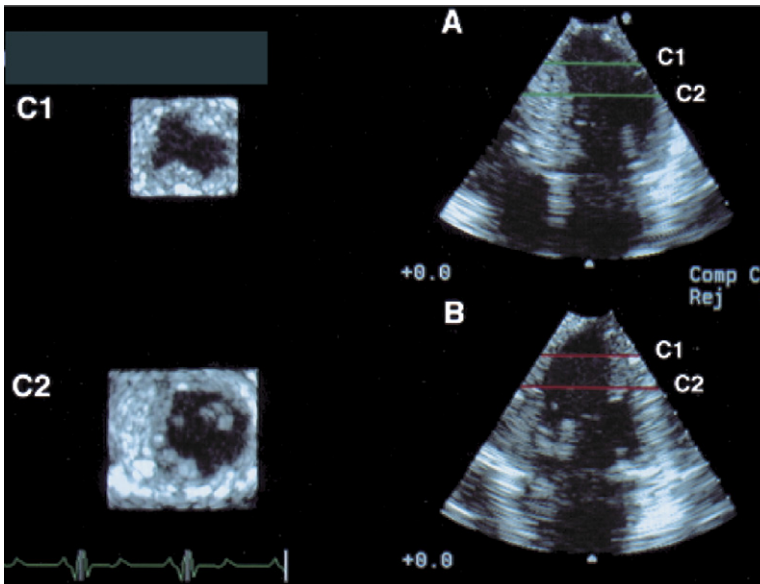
Real-time 3D echocardiograph C-scan images, Volumetrics, Inc. The images shown are apical view of the heart on right, four chamber on top, and two chamber on the bottom. On the left are short axis or C scans of the LV derived from perpendicular cuts through the apical views on the right. (Courtesy of David Adams, RDCS, Durham, NC.)
